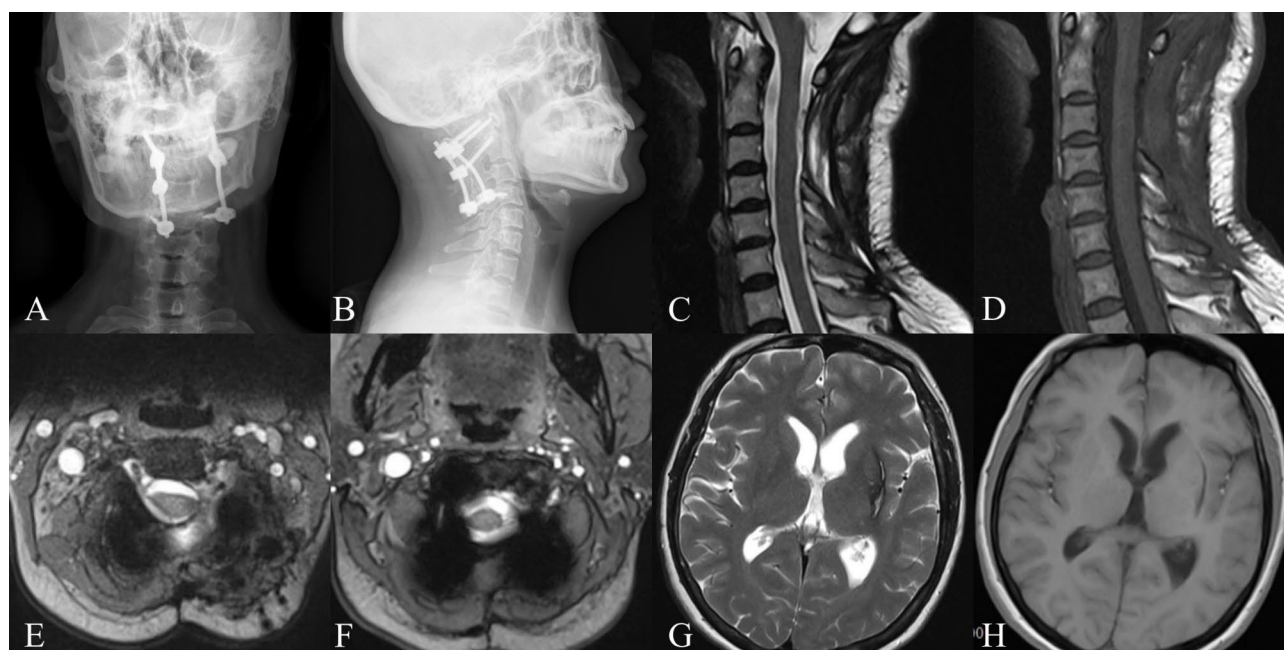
Imaging data of 1 year follow-up after operation: A–B: postoperative X-ray film shows posterior cervical internal fixation in place; C–F: One year after operation, cerebrospinal fluid leakage cavity was obviously absorbed and closed; G–H: Chronic intracranial hematoma in left basal ganglia
